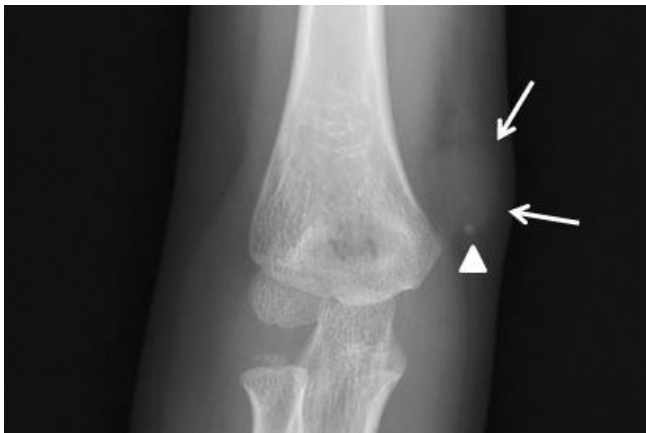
Anteroposterior plain radiographic finding for case. Anteroposterior plain radiograph of the right elbow shows a phlebolith (arrowhead) within the soft tissue mass (arrows).
